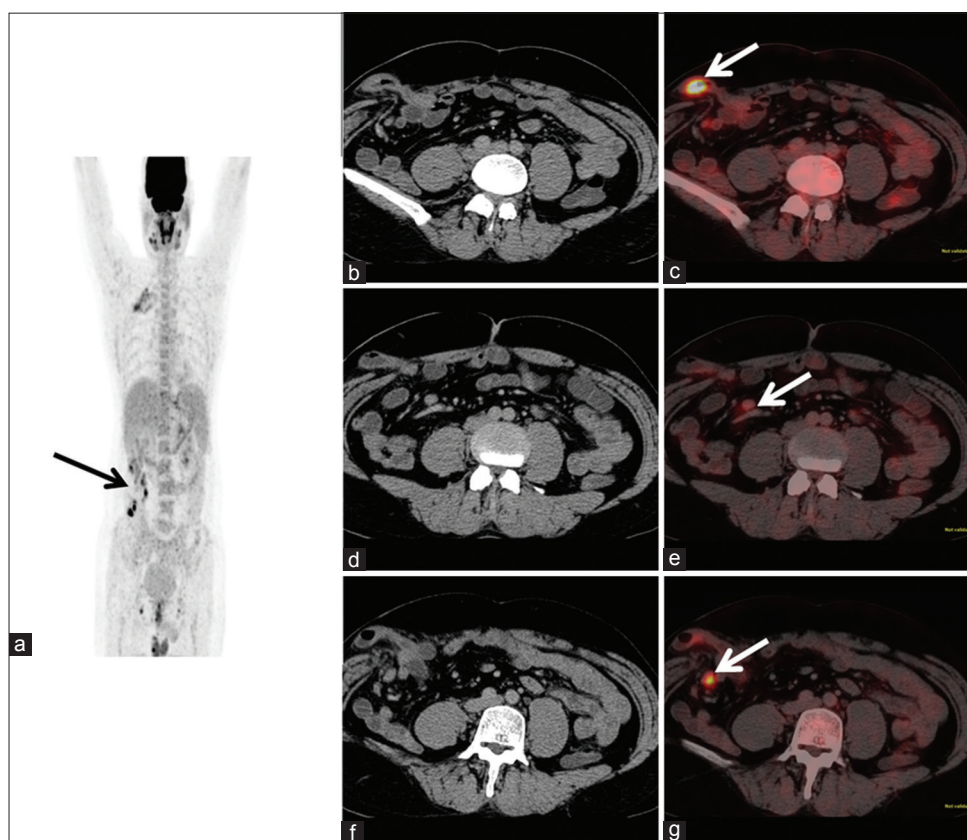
(a) Maximum intensity projection image of ¹⁸F FDG positron emission tomography-computed tomography showing few focal areas of FDG uptake in the right lumbar region. (b) Axial computed tomography image showing thickening in the distal herniated ileal loop showing increased FDG uptake in the fused transaxial positron emission tomography-computed tomography image (c, white arrow). (d and f) Few mesenteric lymph nodes in the para-ileal location in the axial computed tomography image which shows increased FDG uptake in the fused transaxial positron emission tomography-computed tomography (e and g)
